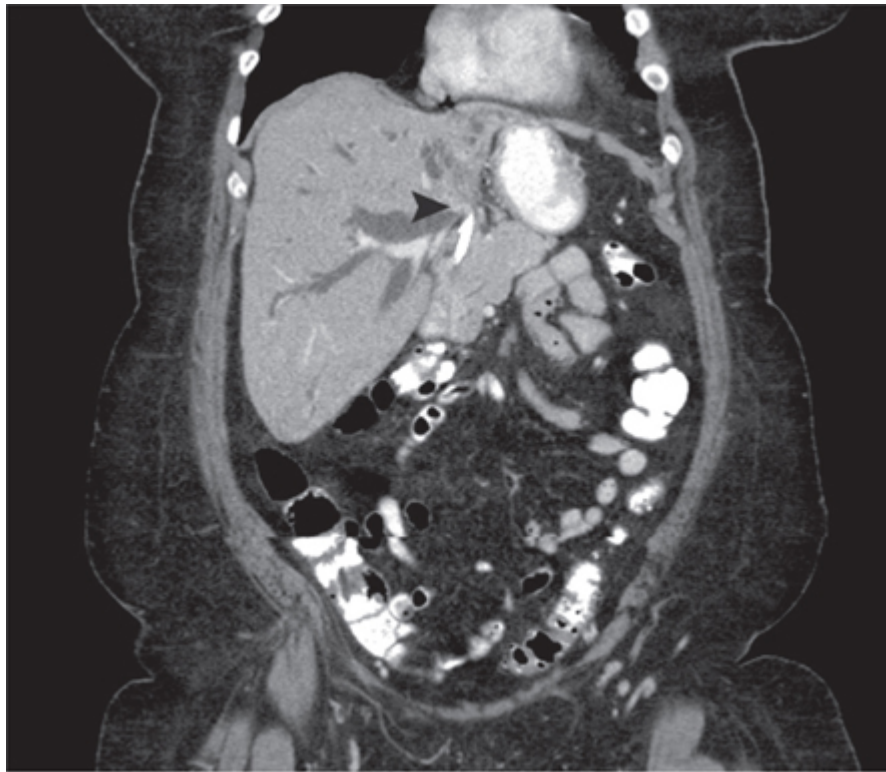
Abdominal computed tomography. There is a tumor occupying the hilum (arrowhead). There is proximal duct dilation in both lobes of the liver, but it is more pronounced in the left lobe. In addition, the left lobe of the liver is atrophied.
